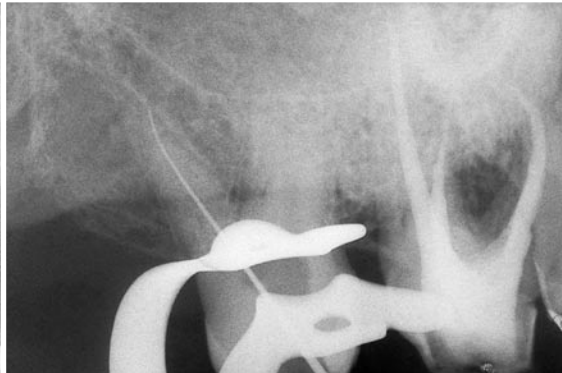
Application of the buccal object rule in the upper second molar. A. The zygomatic process completely hides the apex of the palatal root. B. The X-ray machine has been angled distomesially to mesially to displace the shadow of the zygomatic process, which now appears superimposed on the apices of the first molar.
